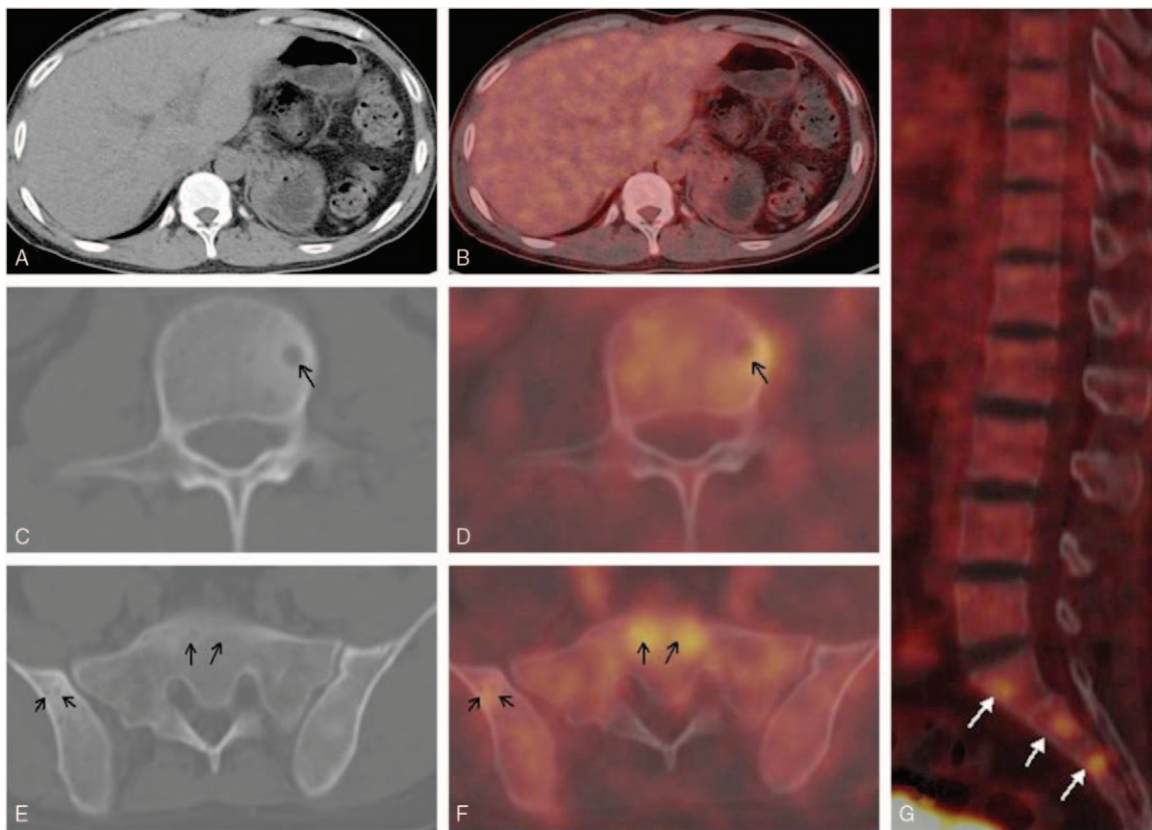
Follow-up whole body positron emission tomography/computed tomography (PET/CT) scan performed 5 months after LTx. The transplanted liver shows normal morphology (A) without abnormal fluorodeoxyglucose uptake (B). Transverse CT and fusion images display osteolytic destruction in the lumbar vertebrae (C, D), sacral vertebrae, and right iliac bone (E, F) with a maximum standardized uptake value of 6.5. Spinal sagittal fusion image (G) shows multifocal sacral lesions postoperatively (arrow).
